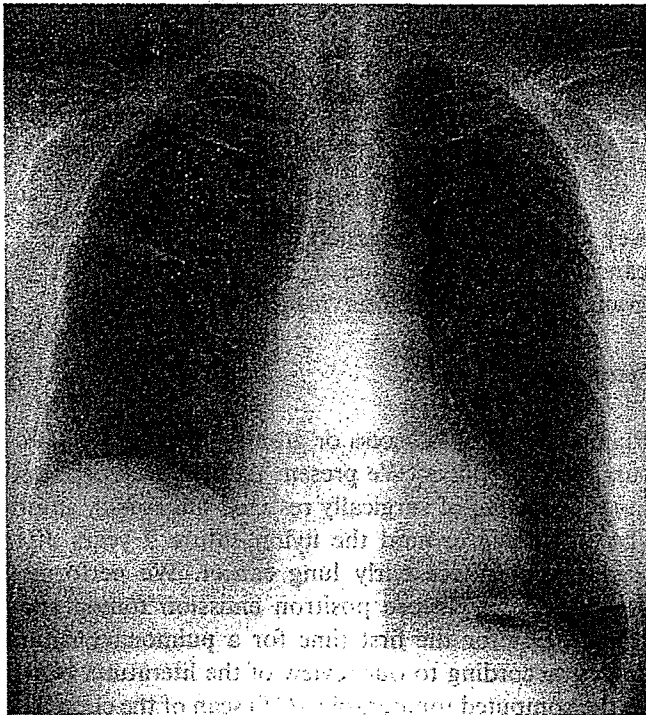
Chest radiograph showing an irregular mass along the minor fissure in the right middle lung field. The mass shadow overlapped with a staple line at the S3 segmentectomy
